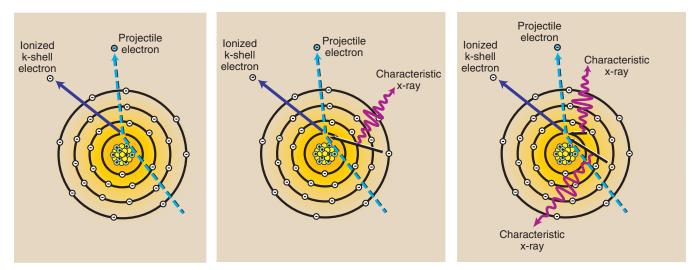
Characteristic x-rays are produced after ionization of a K-shell electron. When an outer shell electron fills the vacancy in the K shell, an x-ray is emitted.
